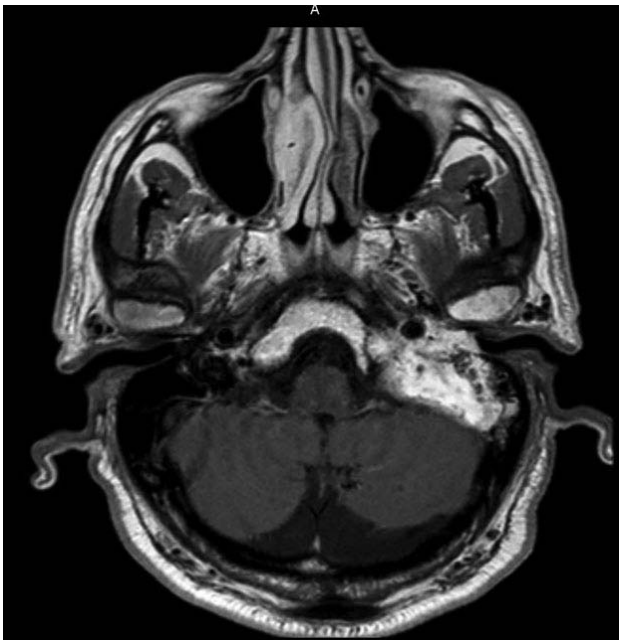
MRI axial T1 post contrast showing avidly enhancing tumor with extension into the left hypoglossal canal and encasement of the left internal carotid artery.
